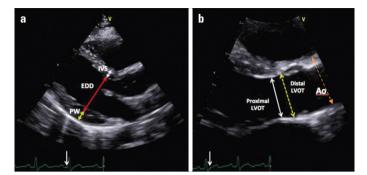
(a) A two-dimensionally guided measurement of LV wall thickness in end-diastole from the left parasternal long-axis view. The interventricular septum thickness (white arrow), LV end-diastolic diameter (red arrow), and the posterior wall (PW; yellow arrow) thickness are measured just distal to the mitral leaflets tips, perpendicular to the long axis of the LV. (b) Proximal LV outflow tract (LVOT) diameter was measured in mid-systole, using the trailing-edge-to leading-edge method, 0.5–1 cm below the aortic cusps in a plane parallel to the aortic annulus (white arrow) from the zoomed parasternal long-axis view. The yellow dashed arrow represents the distal LVOT diameter measured just below the aortic annulus level
